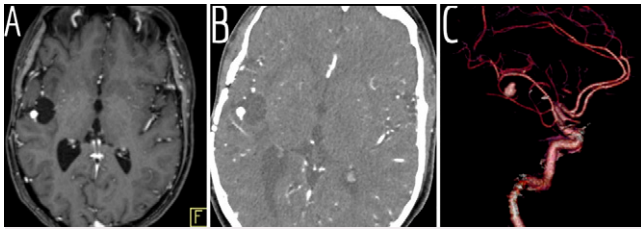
Axial postcontrast T1-weighted MRI (A) with posttreatment cyst and enhancing structure in lateral wall described as a mural nodule. CTA with axial image (B) and three-dimensional reconstruction (C) showing a distal middle cerebral artery branch aneurysm.
